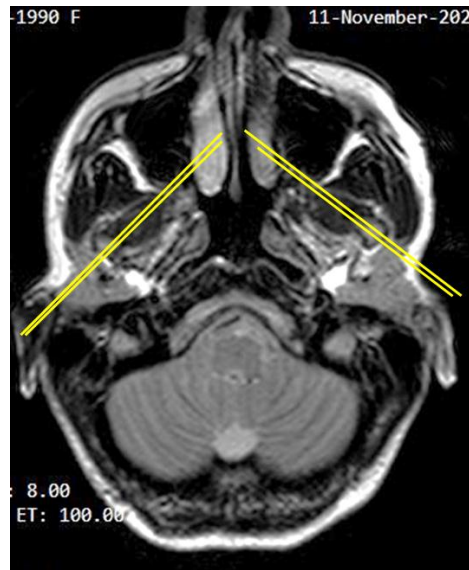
Axial survey MR image showing oblique sagittal lines along with the condylar head and the lateral pterygoid muscle in open mouth position
